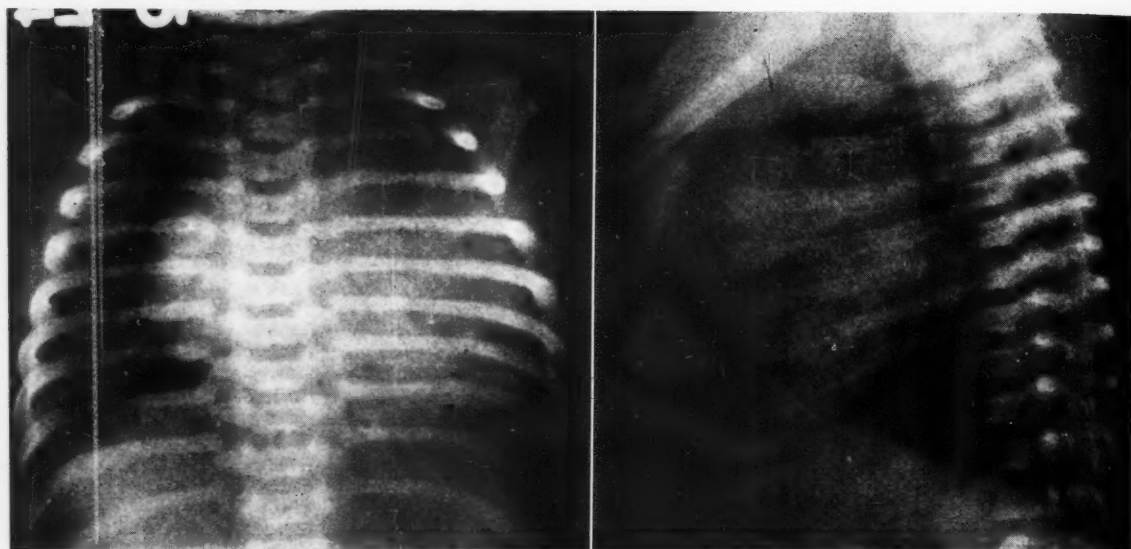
Anteroposterior (left) and lateral (right) thoracic roentgenograms of the 11-day-old female infant who was in congestive heart failure with congenital aortic atresia.
